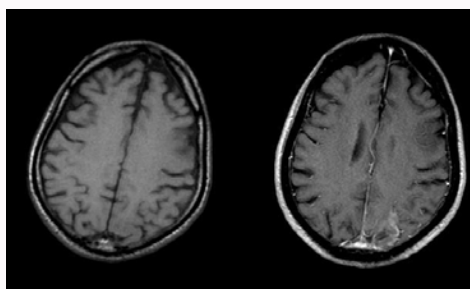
T1-weighted pre and post contrast MRI image showing contrast enhancement in the left occipital area that corresponds with T2 signal abnormality.
